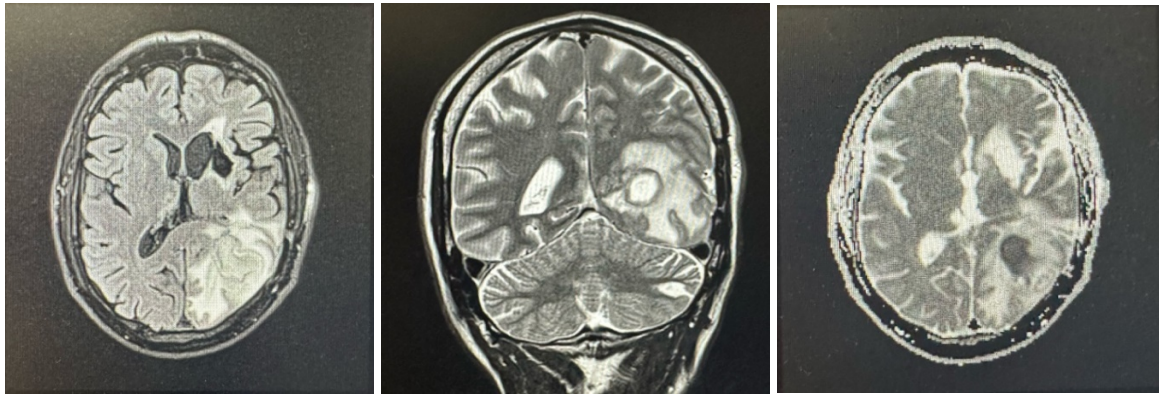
MRI scans of the brain reveal a) an irregular formation in the left temporo-occipital region, measuring up to 32x36x17 mm (anteroposterior x laterolateral x craniocaudal). On T1-weighted images (b) the lesion exhibited hyperintensity in the peripheral region, indicating the presence of potentially enhancing tissue or blood products. In contrast, (c) the T2-weighted images showed hypointensity at the periphery of the lesion, suggesting a complex structure with varying tissue components, possibly including a necrotic core or fibrotic tissue.
